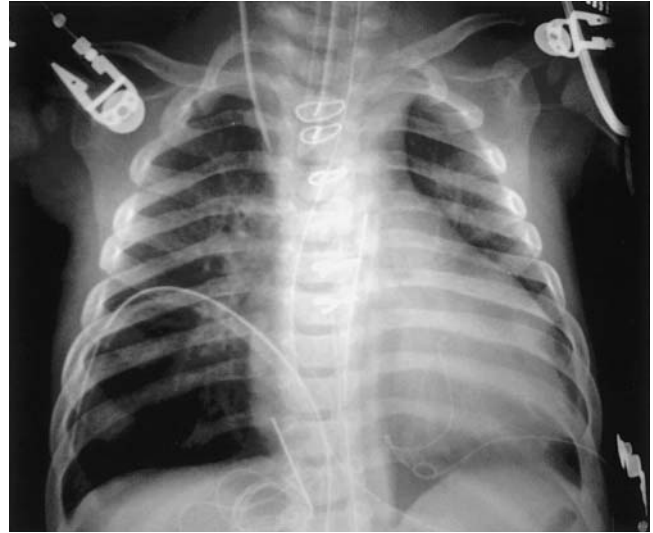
Postoperative chest radiograph with the tip of a right internal jugular vein catheter in the mid-superior vena cava.
